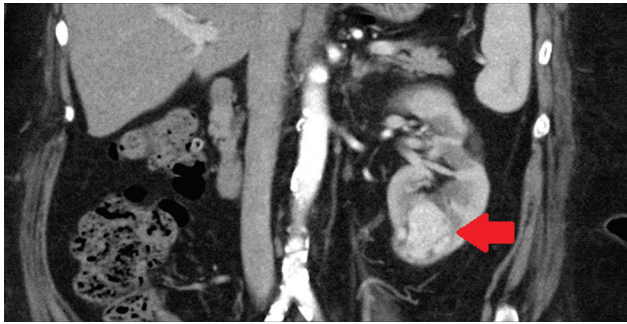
Arterial phase CT with coronal reformats showed a 35 × 35 × 33 mm solid mass at the lower pole of the solitary left kidney (arrow). Biopsy confirmed the imaging diagnosis of renal cell carcinoma.
